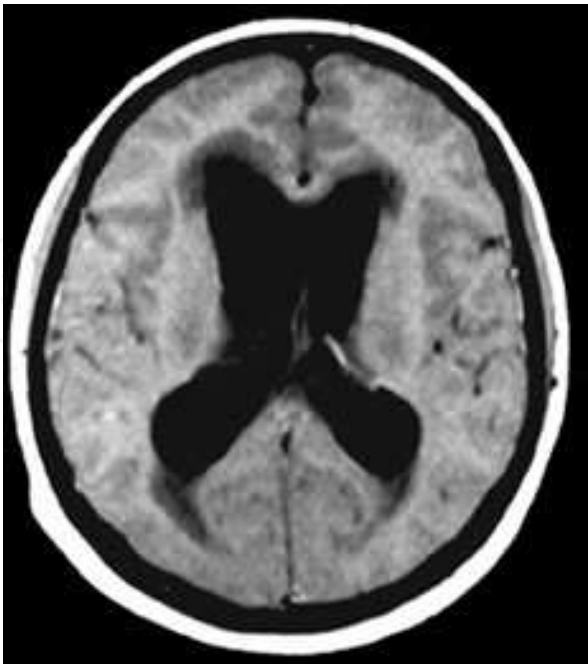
CT scan of the brain at the level of basal ganglia showing enlarged lateral ventricles suggestive of hydrocephalus.
